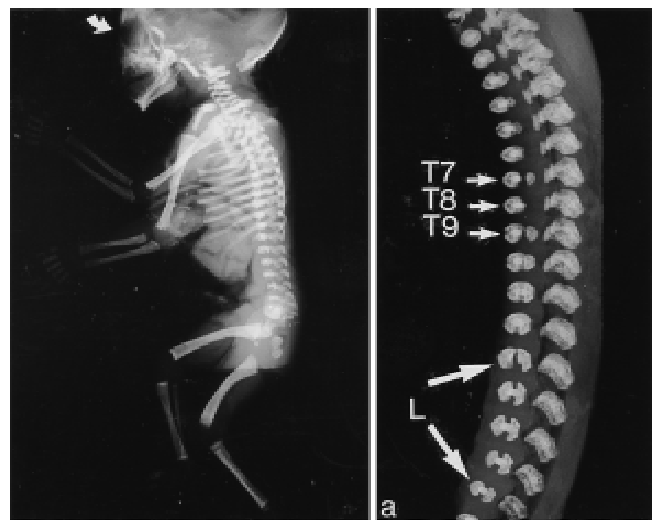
Whole body radiograph in lateral projection (left) of a human trisomy 13 fetus, gestational age 19 weeks,  $\times 0.4$ . The arrow indicates the normal location of the nasal bone, which is absent. a: Radiograph of the thoracic and lumbar vertebrae in lateral projection after dissection of the axial skeleton, shown left  $\times 1.4$  compared to original size. All five lumbar bodies marked L are partly cleft or malformed. Several of the thoracic bodies are malformed, including T7, T8, and T9. Complete vertical clefting of T7 and T9 is seen. In T8 only the anterior part of the vertebral body is ossified.
